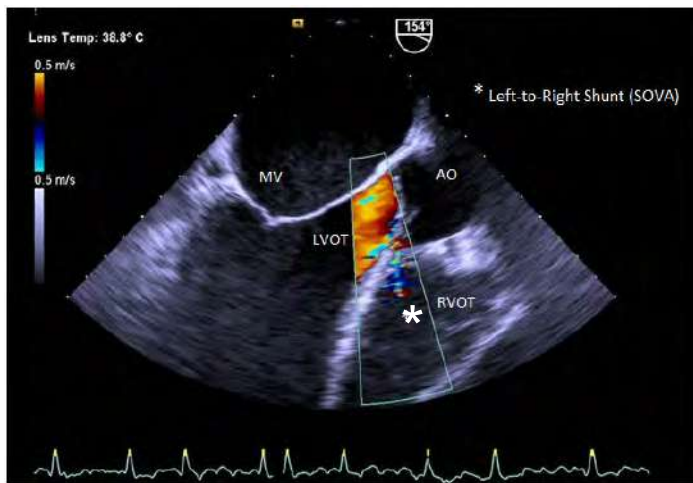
Transthoracic echocardiogram demonstrating a ruptured sinus of Valsalva aneurysm (star). MV, mitral valve; Ao, aorta; RVOT, right ventricle outflow tract; LVOT, Left ventricle outflow tract.
